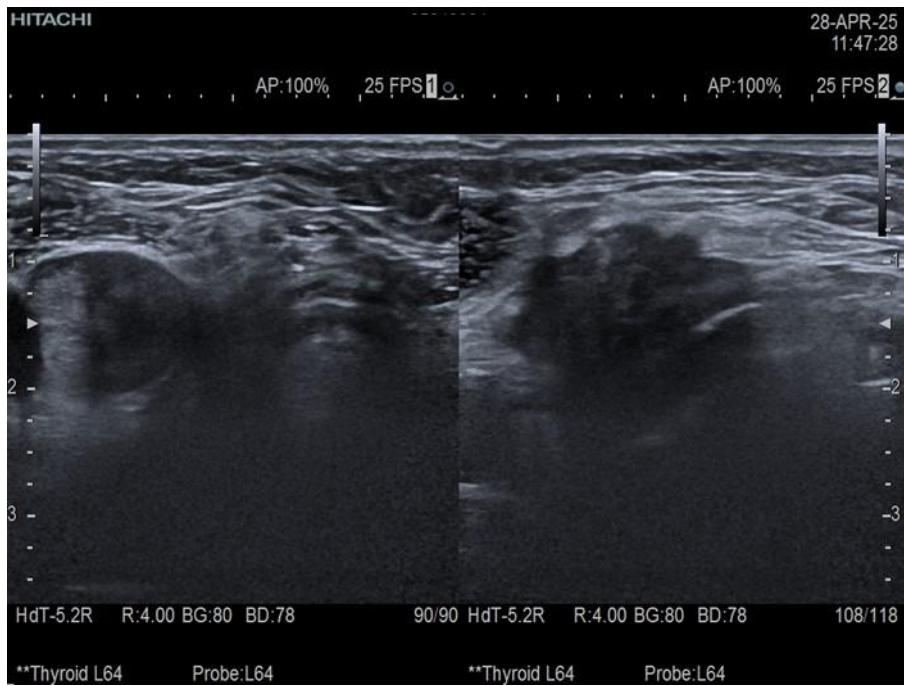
Ultrasound image of the pathological formation in the right thyroid lodge, revealing irregular form and blurred margins –
